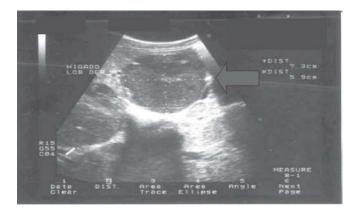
Abdominal sonography showing a large lesion occupying the right liver lobe.
